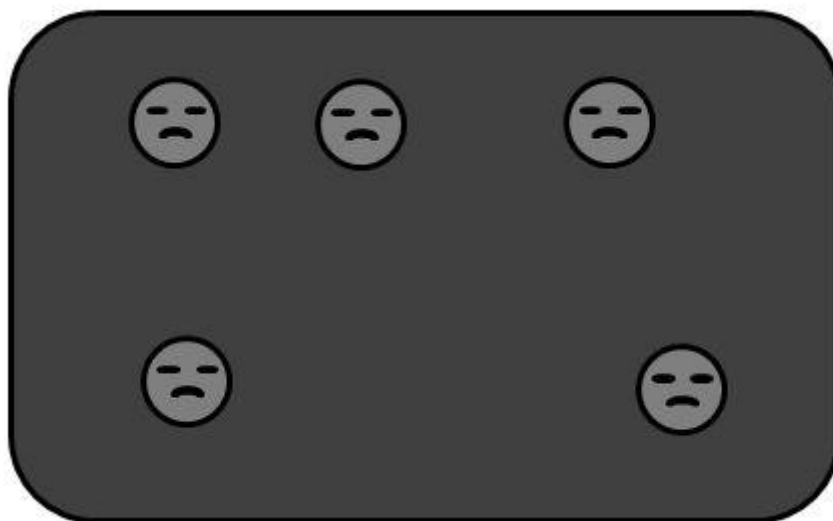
MRI analogy Part 3
